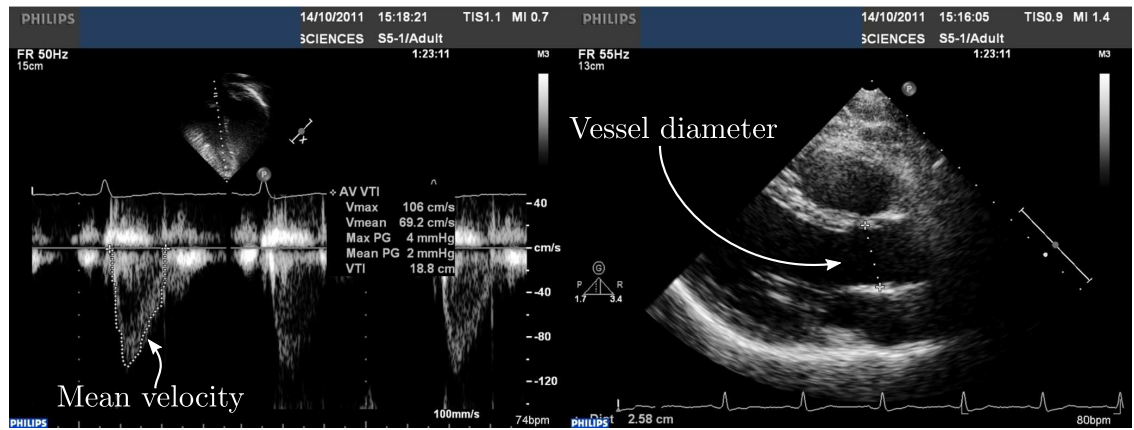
Standard flow quantification using echo Doppler. The echo beam is aligned with the vessel of interest (ascending aorta, on the left). The measured velocity is assumed constant over the cross section. Then, a B-mode image is used to measure the diameter of the cross section (assumed circular, on the right). The resulting flow is calculated as the product of the circular surface and the integral of the measured velocity over time.
